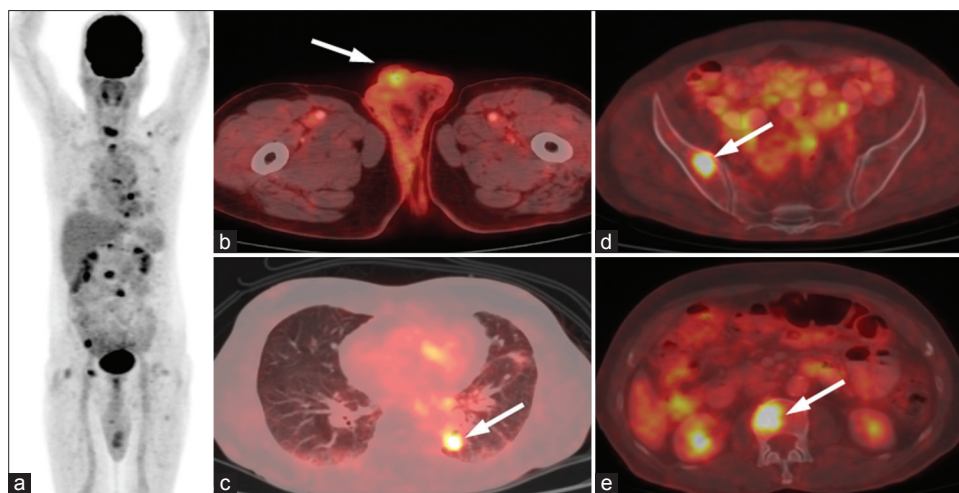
Maximum intensity projection positron emission tomography image. (a) Multiple hypermetabolic foci in thorax, abdomen and pelvis. Transaxial positron emission tomography/computed tomography image of pelvis (b) Postpenectomy status (arrow). No hypermetabolic lesion is seen in the penile stump, and no hypermetabolic inguinal node was seen. Transaxial positron emission tomography/computed tomography image of thorax. (c) Hypermetabolic pulmonary nodules (arrow). Furthermore, seen were multiple hypermetabolic lesions in multiple bones (d and e, arrows). Positron emission tomography/computed tomography findings suggested multiple skeletal and pulmonary metastases
